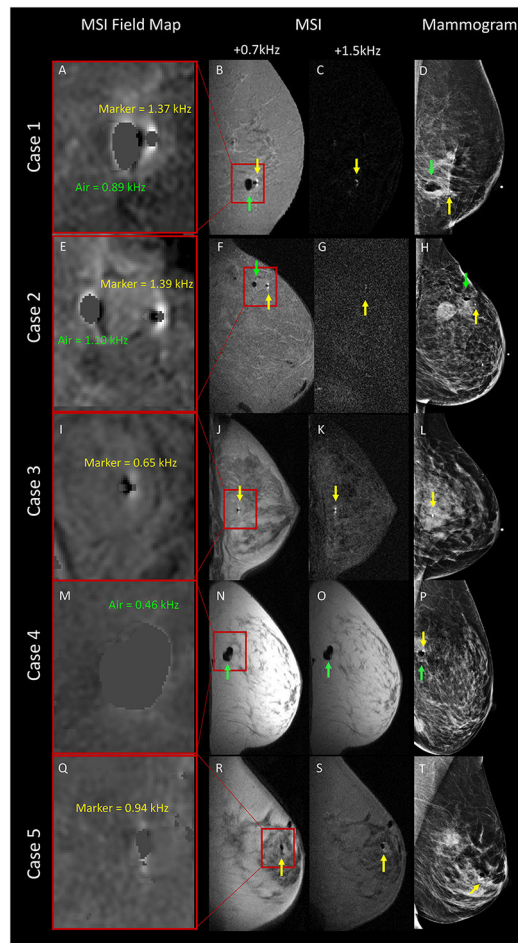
Sagittal MSI field maps insets, sagittal MSI raw data, and mediolateral mammograms performed at the end of MRI-guided breast biopsy in five patients. For MSI field maps (A, E, I, M Q), maximum values of marker-induced and air-induced fields are shown in yellow and green. Cases 1 & 2: a biopsy marker (yellow arrow) and air (green arrow) are present. Case 3: biopsy marker is present (yellow arrow). Case 4: air is present (green arrow). Case 5: challenging case where biopsy marker lands within air cavity. On visual inspection of raw MSI data (R & S), it is unclear whether a biopsy marker is present, however DIMMS correctly identified the marker location within the air cavity. The maximum MSI field map value of 0.94 kHz (Q) was not helpful in confirming the presence of the marker as MSI field map values of up to 1.1 kHz can be seen with air alone (E).
